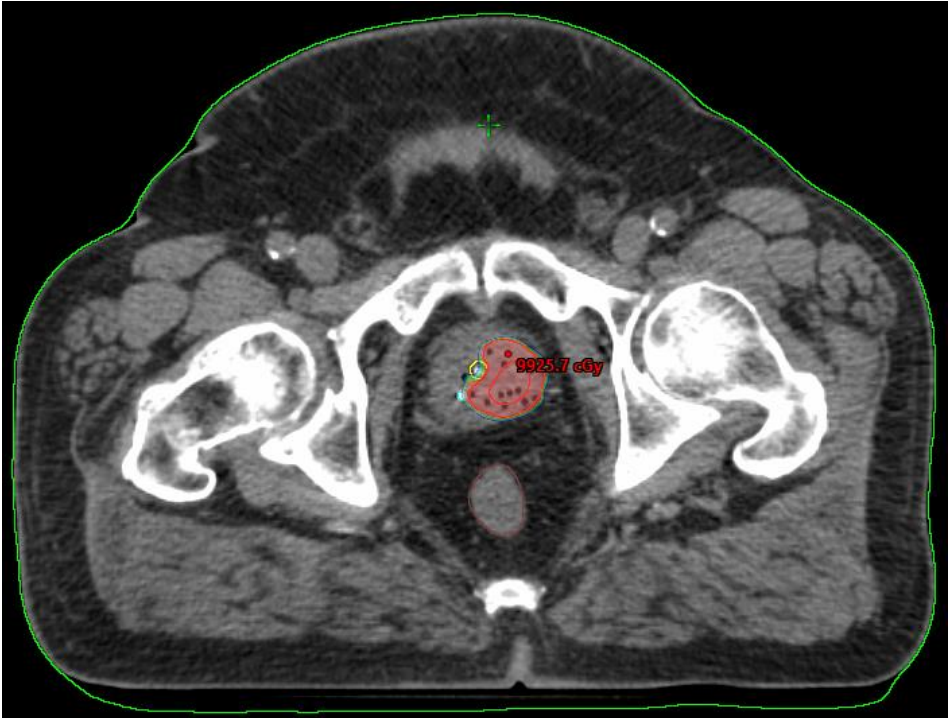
shows the planning MRI images of the 100% isodose line(yellow) covering the CTV(outer red line)
